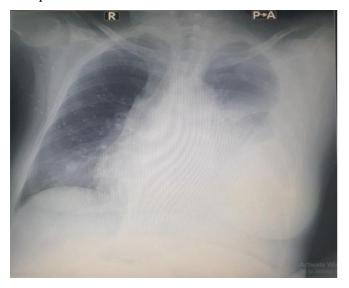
Chest radiograph showing left pleural effusion
